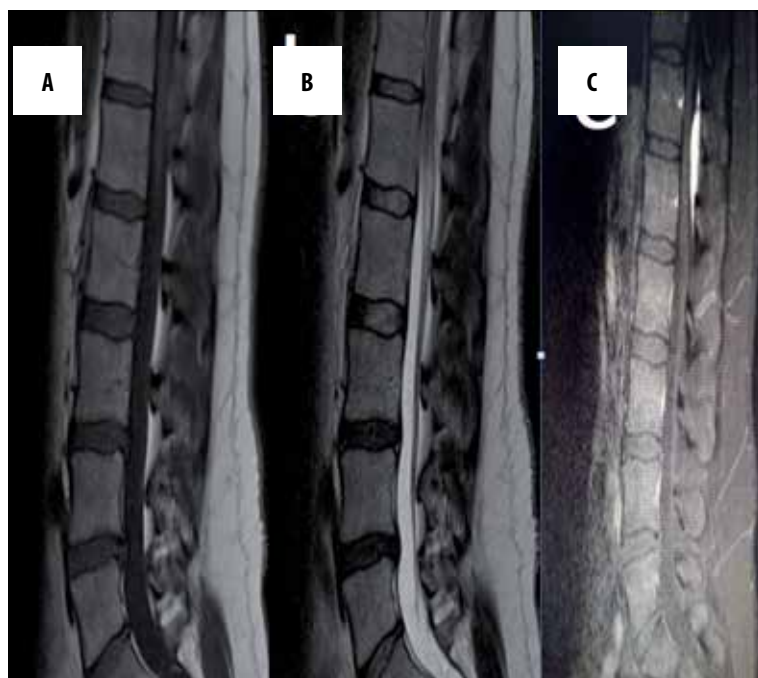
Magnetic resonant imaging, mass lesion along the T12–L1 vertebral levels, which was hypointense on T1-weighted images (A), with a slightly lower signal than CSF on T2-weighted images (B). Heterogeneous gadolinium-enhanced T1-weighted images (C)
